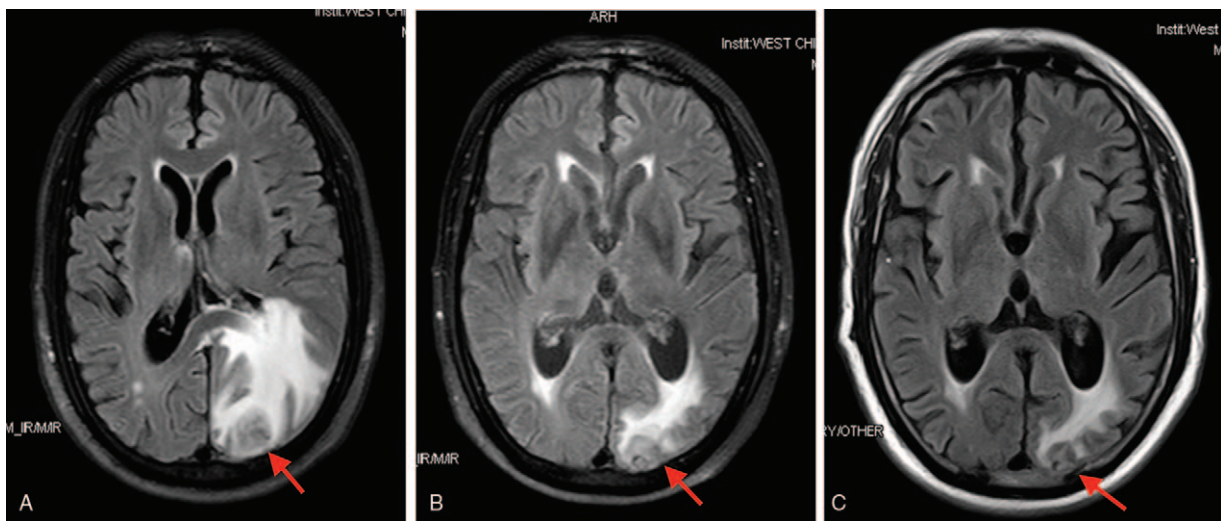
Head magnetic resonance imaging revealed a maximum brain metastasis in the left occipital lobe. (B and C) The maximum brain metastasis showed slight shrinkage after crizotinib and radiation therapy.
